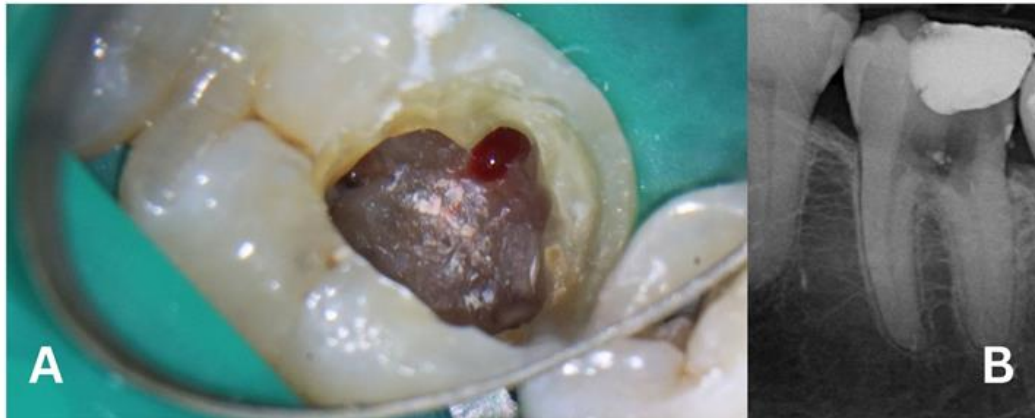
Case 2. Details of the perforation. (A) Intraoperative x-ray showing the perforation of the pulp chamber. (B) Pre operative x-ray where it is noticeable the position of the perforation
